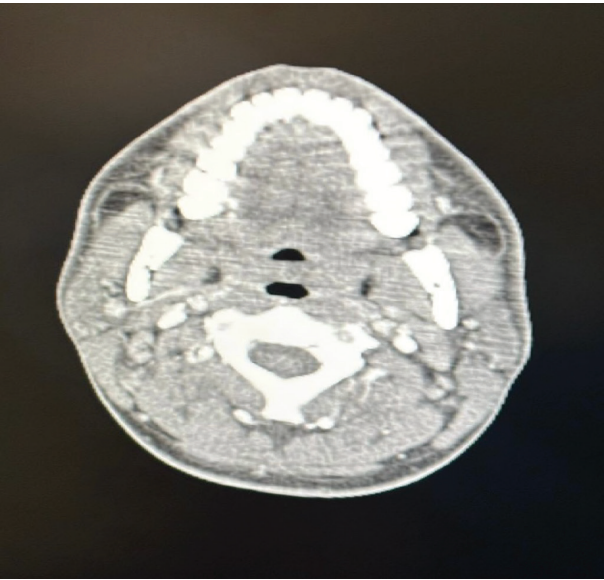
Axial contrast-enhanced CT scan of the head and neck. In this image, there is a soft tissue mass mainly in the gingival area, and it does not show any invasion into the cortical bone below, at all. There are also a few enlarged cervical lymph nodes visible (arrows), and that finding brings up suspicion for a lymphoproliferative disease, or maybe something related - hard to say right away though.
